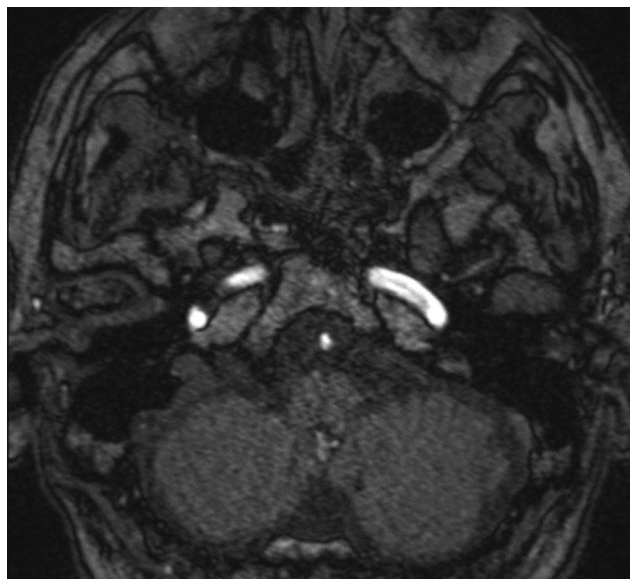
Magnetic resonance imaging time-of-flight showing no recurrence at the 1-year follow-up.
